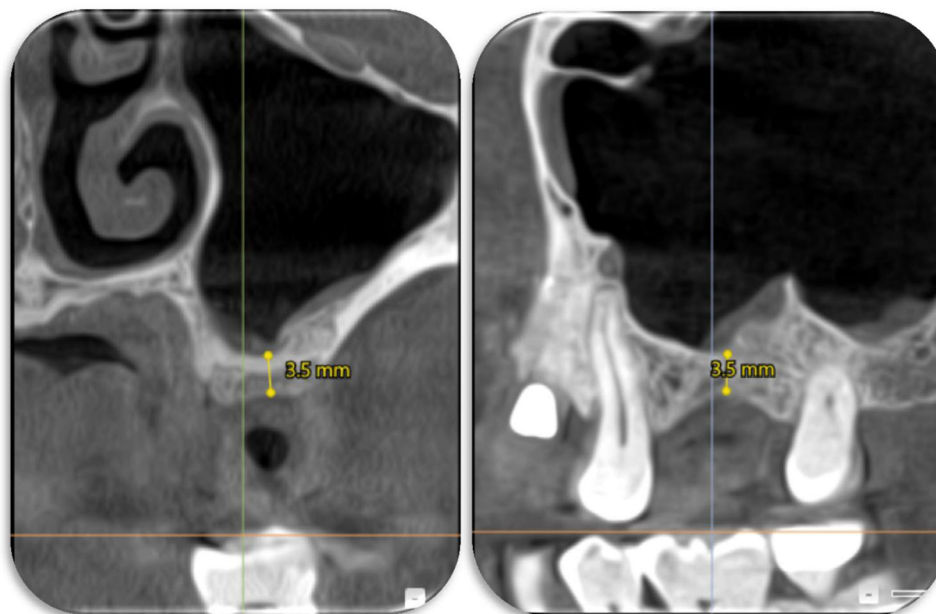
Preoperative CBCT. Approximately 3.5 mm of vertical bone height is present at the #14 edentulous site.
